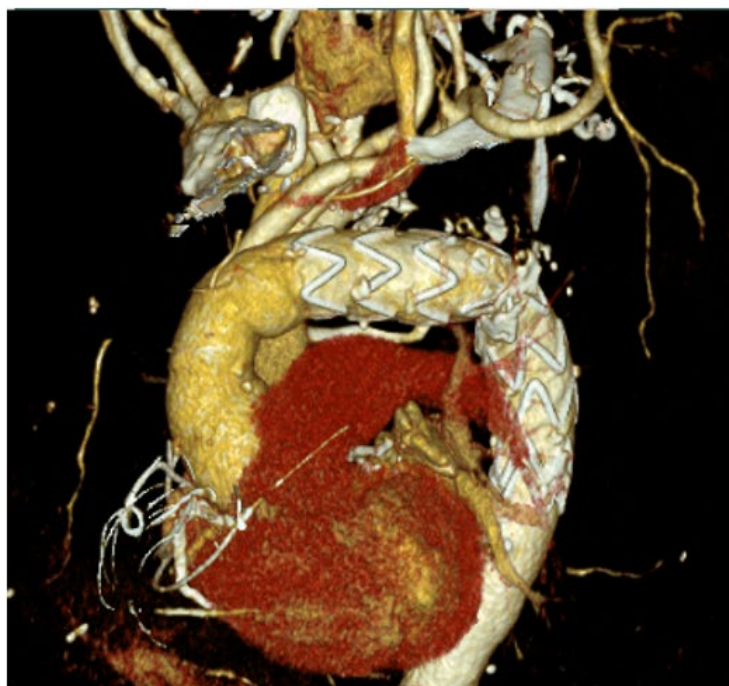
Postoperative computed tomography reconstruction demonstrating ascending aortic and total arch repair performed via a minimally invasive approach through partial upper sternotomy.
